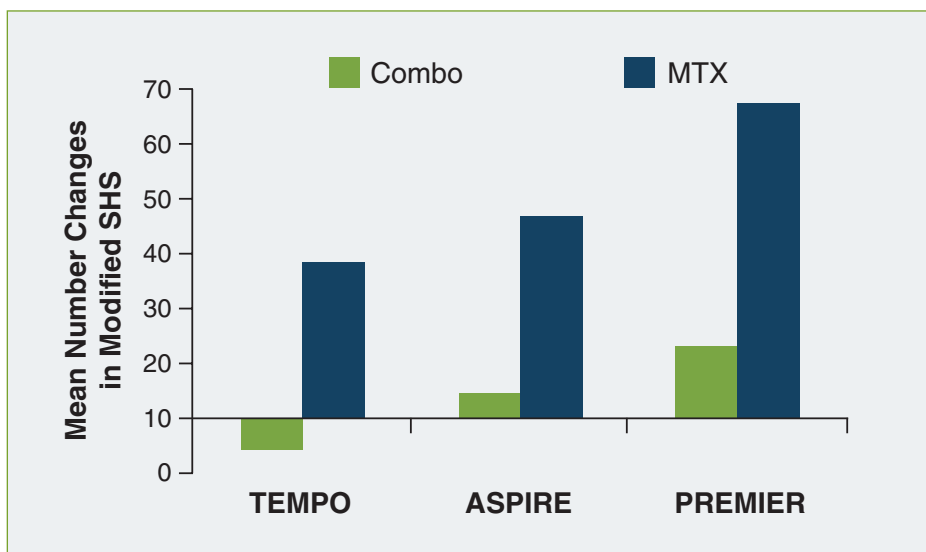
Greater radiographic improvement with TNF- α agents plus MTX compared to MTX alone in 3 similarly designed clinical trials: TEMPO,⁴ ASPIRE,⁵ and PREMIER.⁸ Mean numeric changes in the modified SHS are shown. Adapted from Weisman MH.¹⁰
